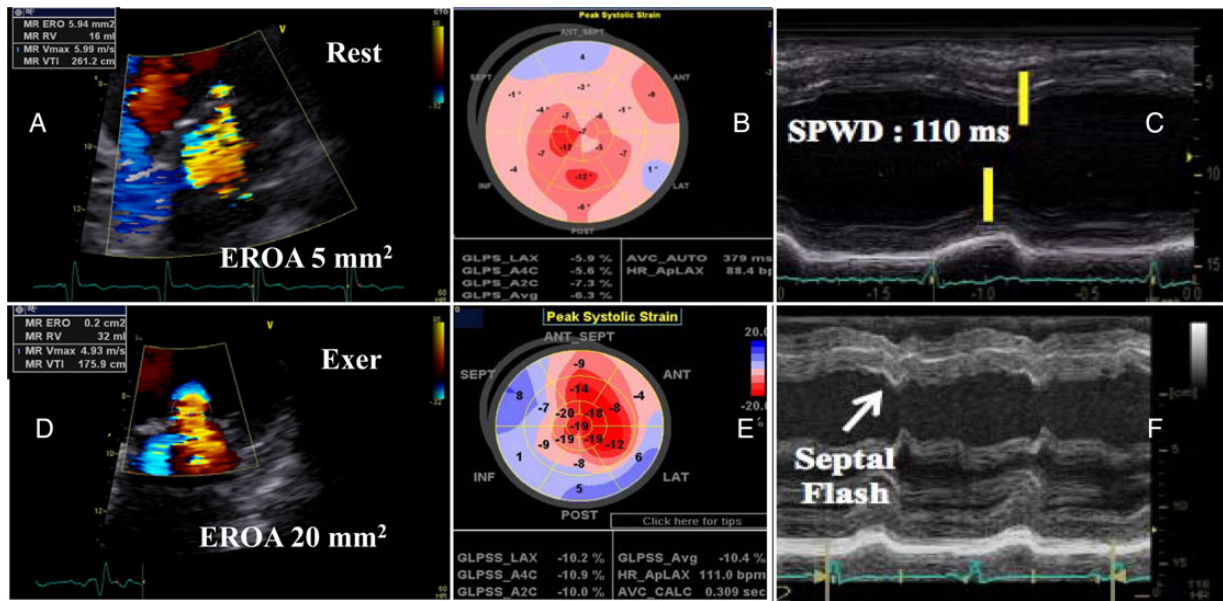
Patient with idiopathic cardiomyopathy and limited exercise capacity. (A–C) Rest evaluation; (D–F) exercise echocardiography results. From rest to exercise, there is an increase in mitral regurgitation severity (A and E) and in left ventricular dyssynchrony (B–F). (A and D) increase in effective regurgitant orifice area (EROA) during test. (B and F) Bulls-eye figures of longitudinal peak systolic strain values in the LV. From rest to exercise, global strain increases (–6.3% to –10.4%) indicating the presence of contractile reserve. During exercise, there is a significant dyssynchrony between the infero-lateral wall and the anteroseptum wall (regional strain color-coded changes from orange to blue). (C and F) M-Mode echocardiogram showing the occurrence of a septal flash (rapid inward motion of the septum within the isovolumic contraction period) at exercise. SPWD, septal posterior wall motion delay.
